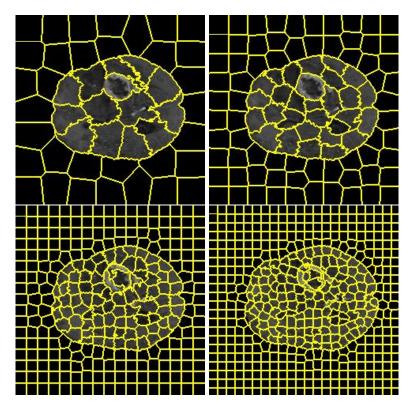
Brain MRI slice super-pixel segmentation for different values of K (number of super-pixels). Top-left 50. Top-left 100. Bottom-left 300. Bottom-right 500
